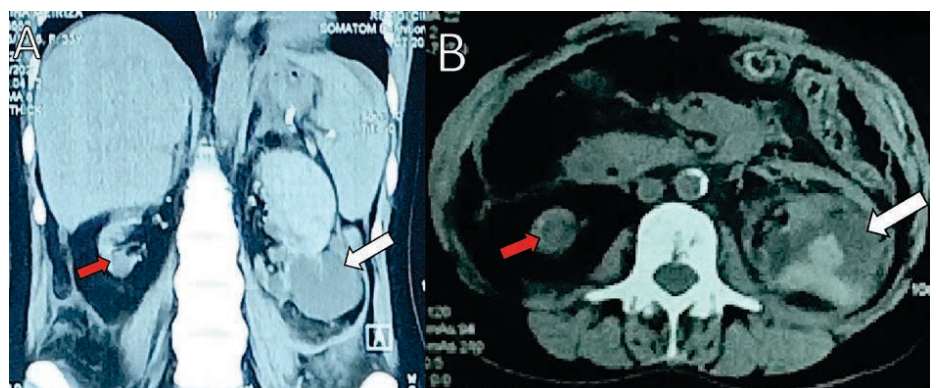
Non-contrast abdominal CT scan. (A) Coronal view. (B) Axial view. Isodense area in the cyst at lower pole (white arrow), contracted right kidney (red arrow).
